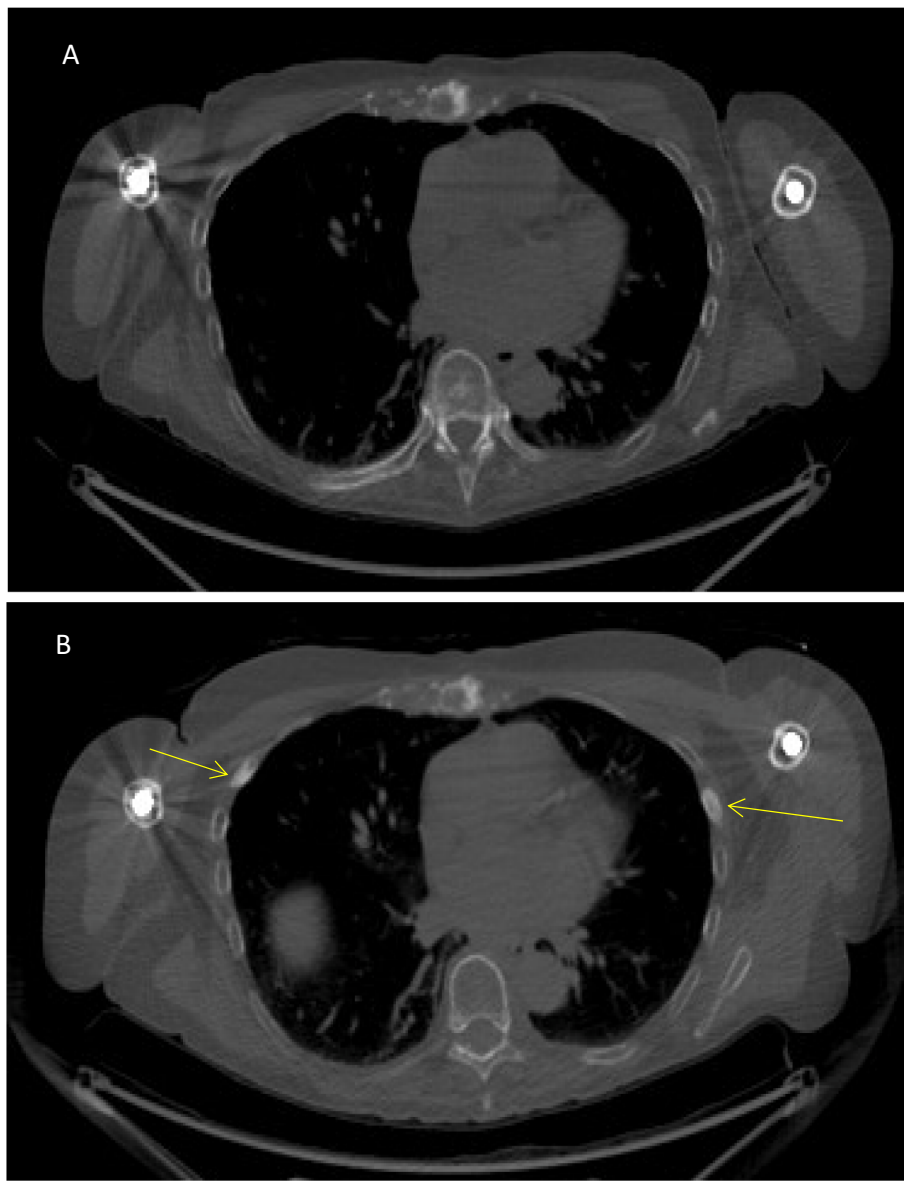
Case 2: (A) CT component of F18 PET CT 2014 and (B) CT component of F18 PET CT 2015, equivalent slice. Arrows indicate sclerotic reaction related to bilateral rib stress/insufficiency fractures.
